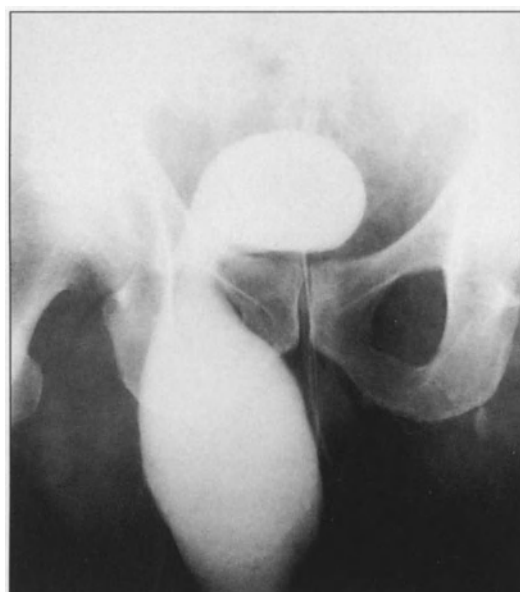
Abnormal voiding cystourethrography (VCUG) results. A, VCUG of an elderly man with lower urinary tract symptoms and radiographic evidence of bladder outlet obstruction. The bladder neck and prostatic urethra appear narrow. B, VCUG of an elderly man after transurethral resection of the prostate. The prostatic fossa is wide and the bladder neck is open. There is no evidence of bladder neck contracture or filling defect, suggesting incomplete resection or prostatic regrowth.
